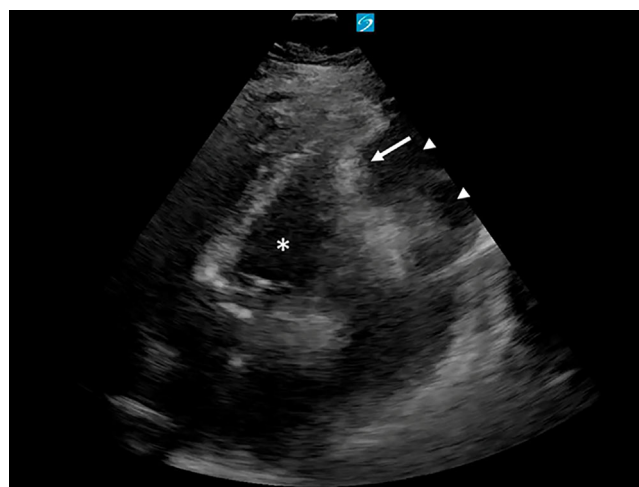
Apical 4-chamber view centered on left ventricular cavity (asterisk) with focal left-sided pericardial effusion (arrowheads) causing diastolic left ventricular free wall collapse (arrow).
